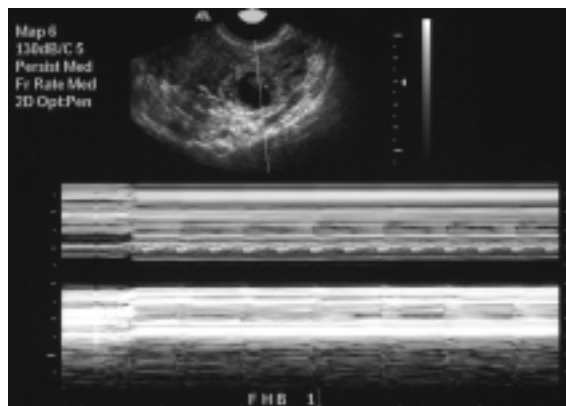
M-mode Doppler US trace of the other echogenic component in the left adnexal mass.
